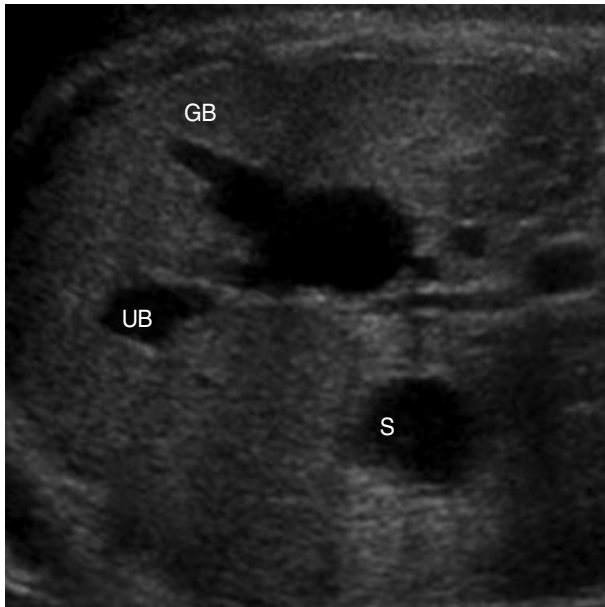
Prenatal 2-D ultrasound scan at 22 weeks of gestation with an intrahepatic anechoic cystic structure ( $2.37 \times 1.75$  cm). GB, gallbladder; UB, umbilical vein; S, stomach.
